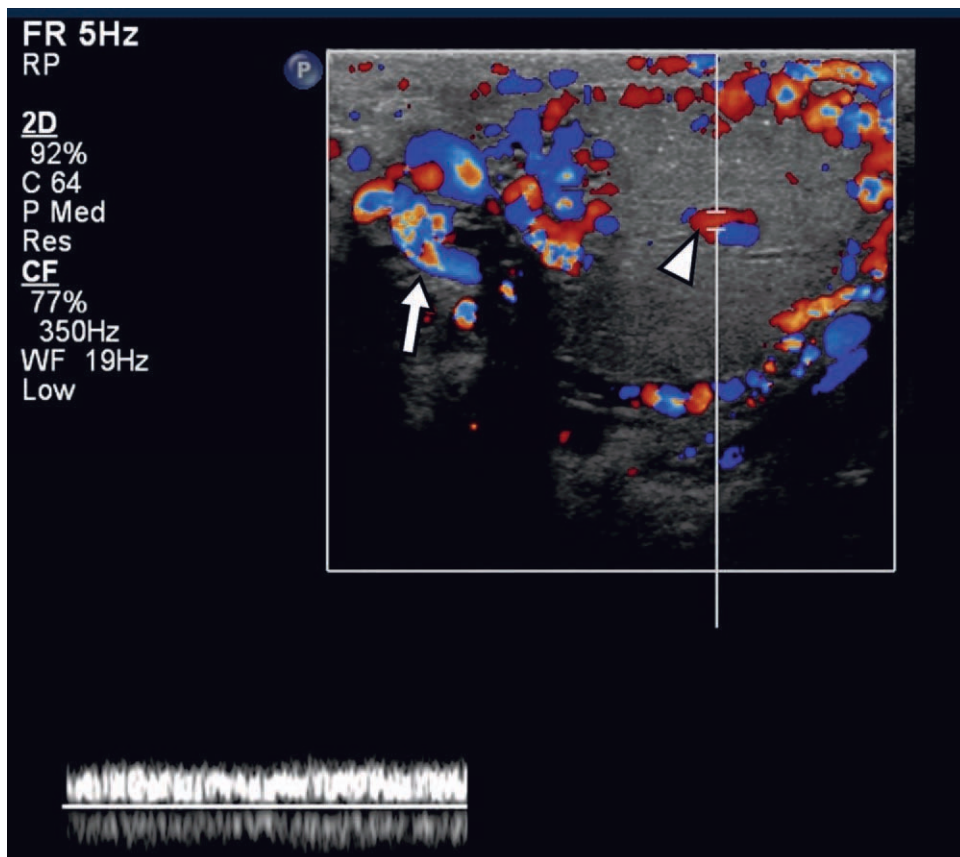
Spectral Doppler analysis of the left intratesticular varicocele (arrowhead) demonstrates a venous flow pattern. The extratesticular varicocele is also seen in this image (arrow). Both varicoceles slightly increased with Valsalva maneuver.
